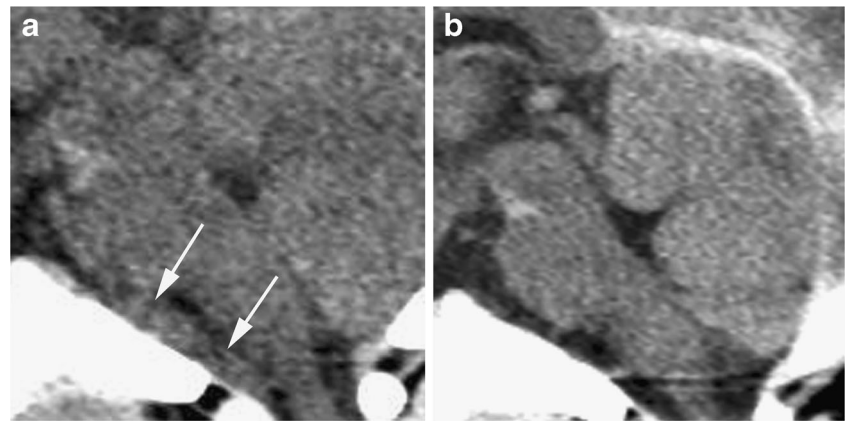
CT and MRI in a 7-month-old girl with a retroclival subdural collection (case 11). a Sagittal reformatted CT image performed 2 days post symptom onset shows the subdural collection (*long arrows*) as intermediate in density. Note the retroclival collection is superficial to the tectorial membrane (*short arrow*). b Sagittal reformatted CT image
